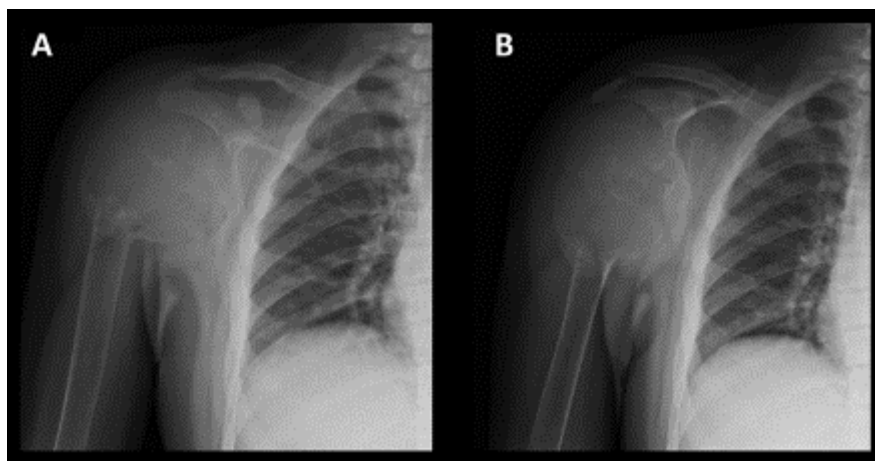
A-B Anteroposterior radiograph (Fig. 1-A) and internal rotation view (Fig. 1-B) of the right shoulder showing a radiolucent lesion with a non-sclerotic margin and eccentric cortical erosion of the proximal humerus, extending from the humeral head to the proximal third of the diaphysis, with involvement of surrounding soft tissues.
